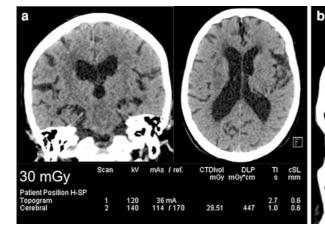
Optimized Brain CT acquisition obtained with 40×0.6 collimation, 140 kV, activated tube current modulation (in Z-axis), image quality reference mAs at 170. The
